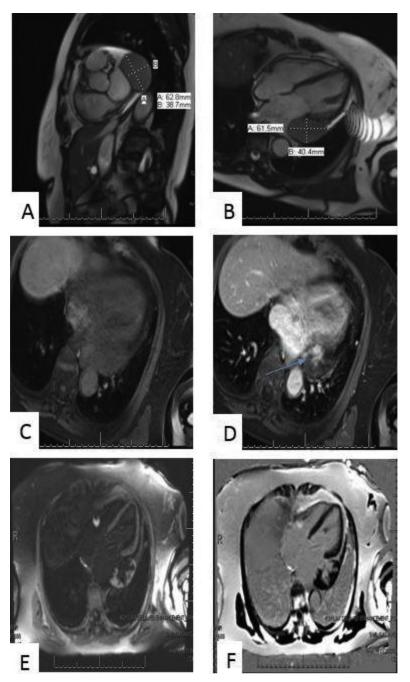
Cardiac MRI: (A) T1-weighted short-axis, sagittal view of cardiac mass compressing the left atrium. (B) T2-weighted fourchamber axial view of cardiac mass that appears within pericardium and does not extend into the left atrium. (C,D) T1-weighted fourchamber gradient-echo sequence with fat saturation before and after contrast showing rapid central, heterogeneous enhancement of the mass (*blue arrow*) indicative of significant blood supply. Delayed enhancement MRI: (E) T1-weighted and (F) T2-weighted fourchamber axial views showing mass that is isointense or slightly hyperintense to surrounding myocardium.
